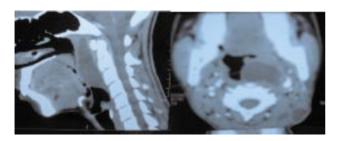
Computed Tomography neck showing retropharyngeal abscess without damage to cervical spine and abscess in cervical lymph node on left side.
